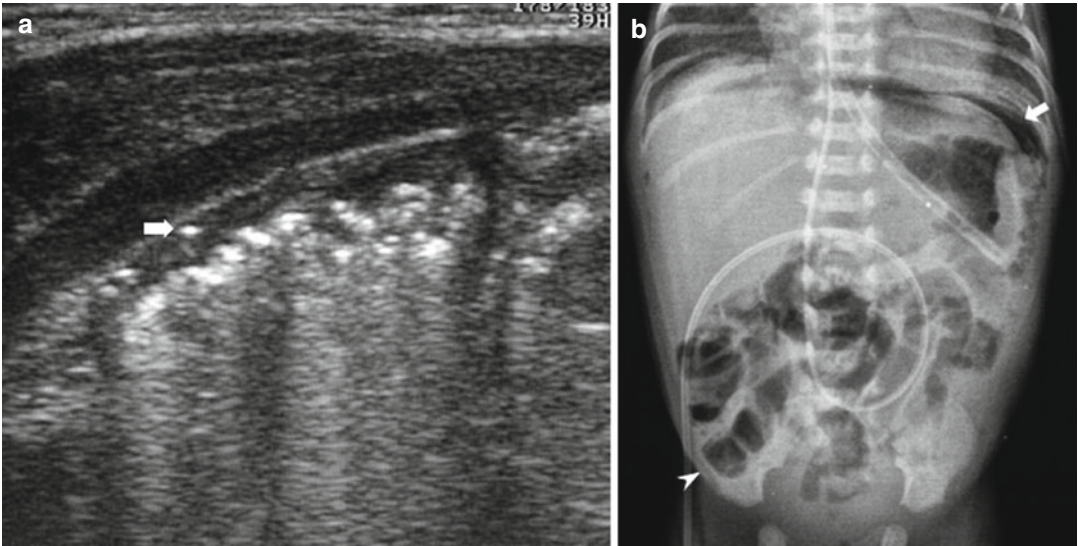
(a) Ultrasound exam in newborn with NEC with parietal pneumatosis (*white arrow*); note the posterior reverberation artifacts. (b) Plain film shows the pneumatosis (*arrowhead*) and pneumoperitoneum (*arrow*)
